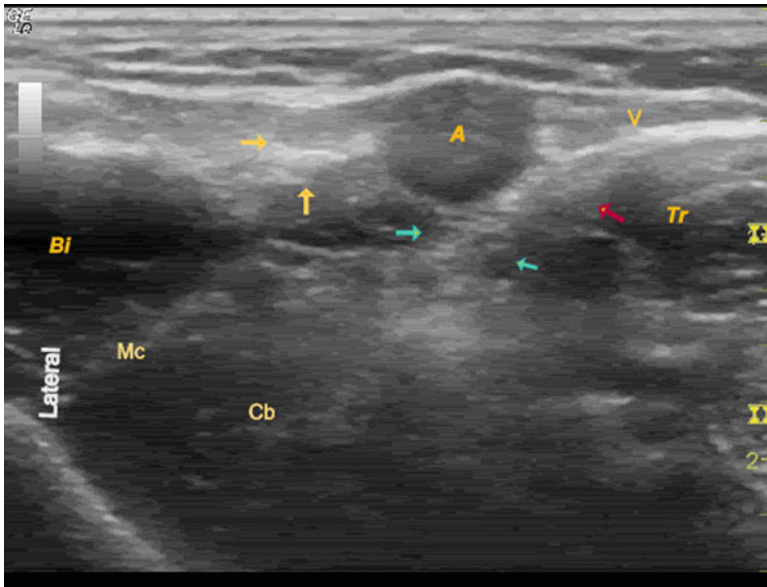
The ultrasonography of the axillary nerve block. The axillary artery (A) is located centrally, bounded laterally by the biceps muscle (Bi) and medially by the triceps muscle (Tr) and compressible axillary vein (V). The terminal nerves surrounding the artery are the median nerve (yellow arrows), the radial nerve (blue arrows), and the ulnar nerve (red arrow). The musculocutaneous nerve (Mc) is separately blocked as it runs in between the biceps and the coracobrachialis (Cb)
